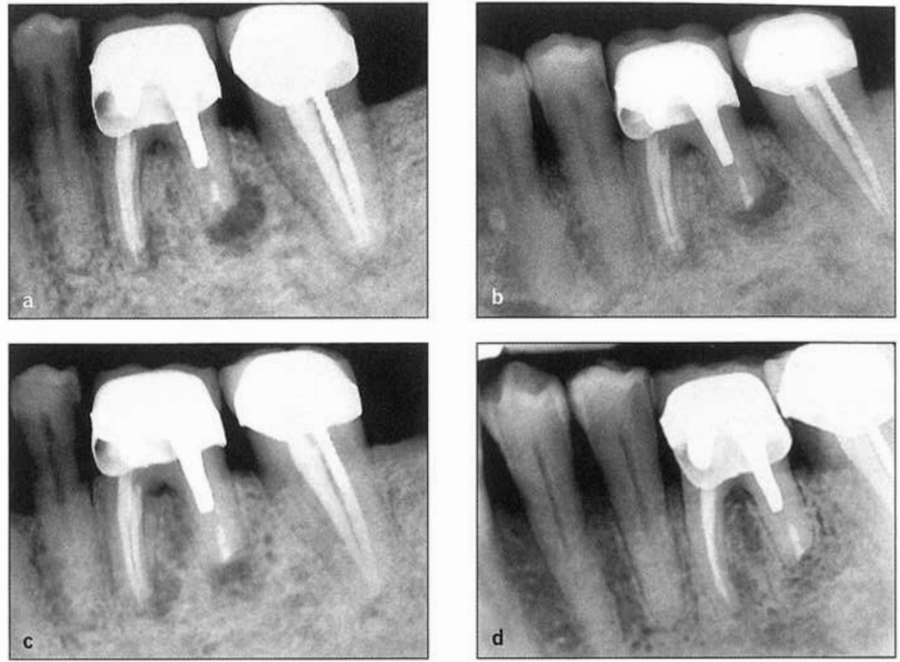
(a) Post placement and incomplete root canal obturation resulting in formation of a symptomatic periapical lesion. (b) Immediately after placing MTA as a root-end filling during intentional implantation. (c) Follow-up at 18 months. (Courtesy of Dr Hamed Manochehrifar, Kerman, Iran.)
